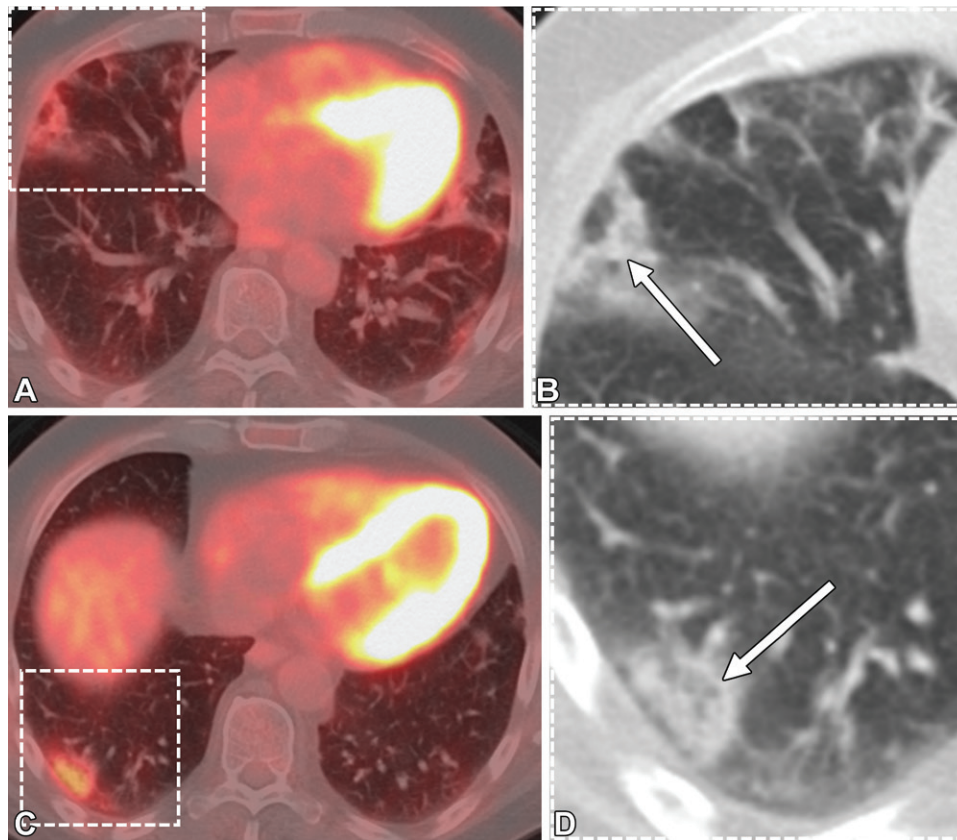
Organizing pneumonia secondary to graft versus host disease in a 60-year-old man with mantle cell lymphoma after allogeneic stem cell transplant. (A, C) Transaxial fused restaging FDG PET/CT images 2 years after stem cell transplant show new, mildly hypermetabolic peripheral consolidation and GGO, with the inset area in A magnified in the corresponding CT image (B) and the inset area in C magnified in the corresponding CT image (D). (B, D) The magnified CT images highlight characteristic CT findings of organizing pneumonia, including a perilobular pattern of consolidation (arrow in B) and the reverse halo sign (or atoll sign) of consolidation with central GGO (arrow in D).
